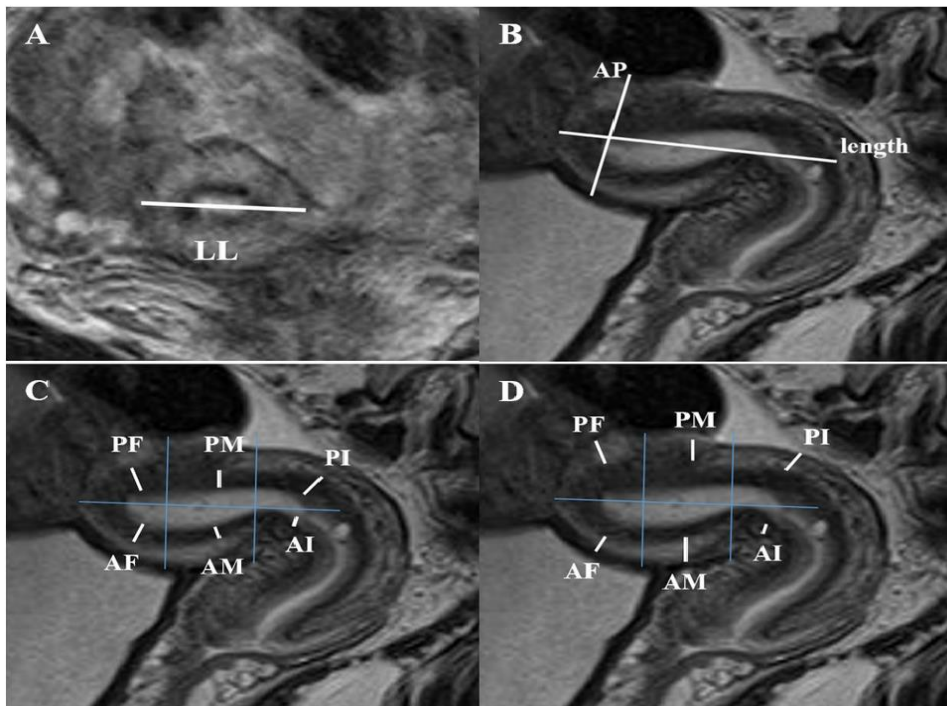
Measurements of the corpus uteri volume, the junctional zone thickness and outer myometrium thickness, assessed on T₂-weighted turbo spin echo magnetic resonance images. A: The transversal image obtained before buscopan injection was used to measure the corpus size latero-lateral (LL). B: On the sagittal image after
